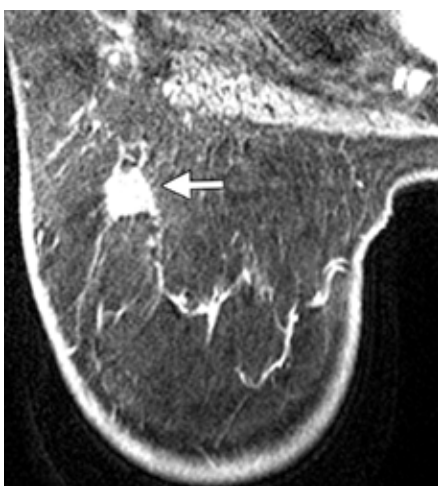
MR shows primary breast lesion in a patient with IBC, who had no detectable lesion on mammography and initial ultrasound
